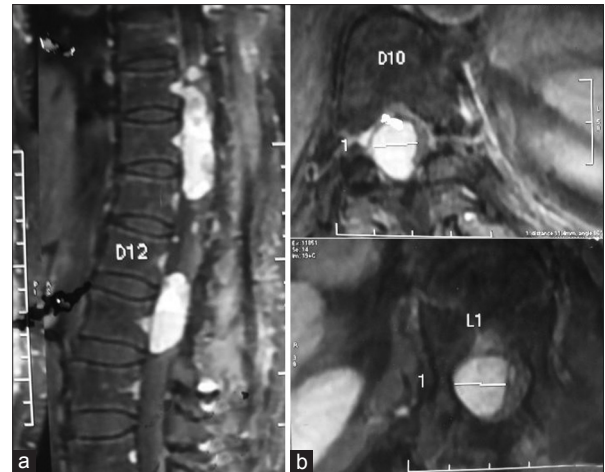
(a and b) MRI revealed another right sided intradural extramedullary lesion extending from D-8 to D-10 level and compressing cord, after 1 year of first surgery
